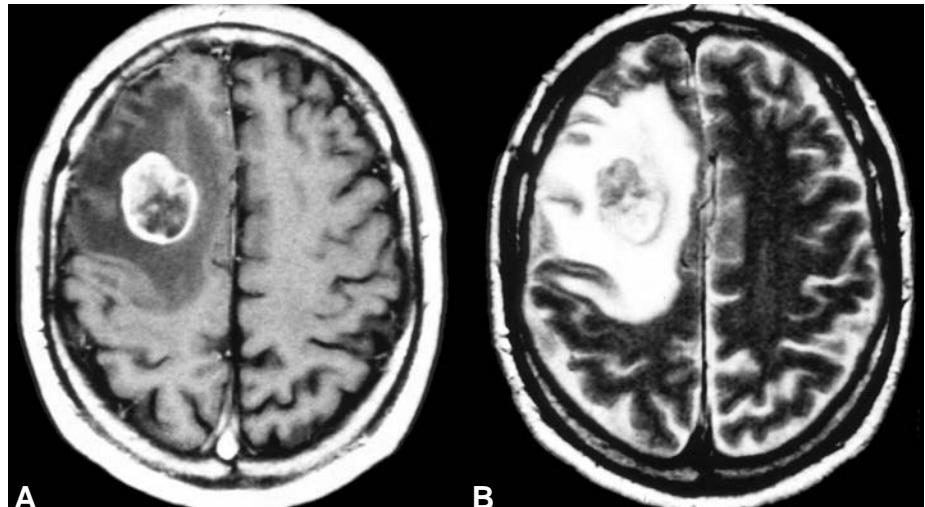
Metastasis of an adenocarcinoma in the right frontal lobe. A Gadolinium-enhanced T1-weighted MRI showing a large area of hyperintensity corresponding to a perifocal edema that (B) shows bright hyperintensity on T2-weighted MRI.
